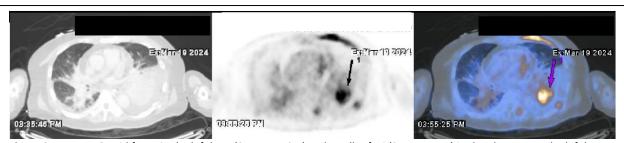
Large FDG-avid focus in the left lung (SUVmax 12.1) and smaller foci (SUVmax 4.4) in the pleura near the left lung base, confirming the primary malignancy. These were obscured on CT by the consolidation with pleural effusion and compressive atelectasis in both lungs
